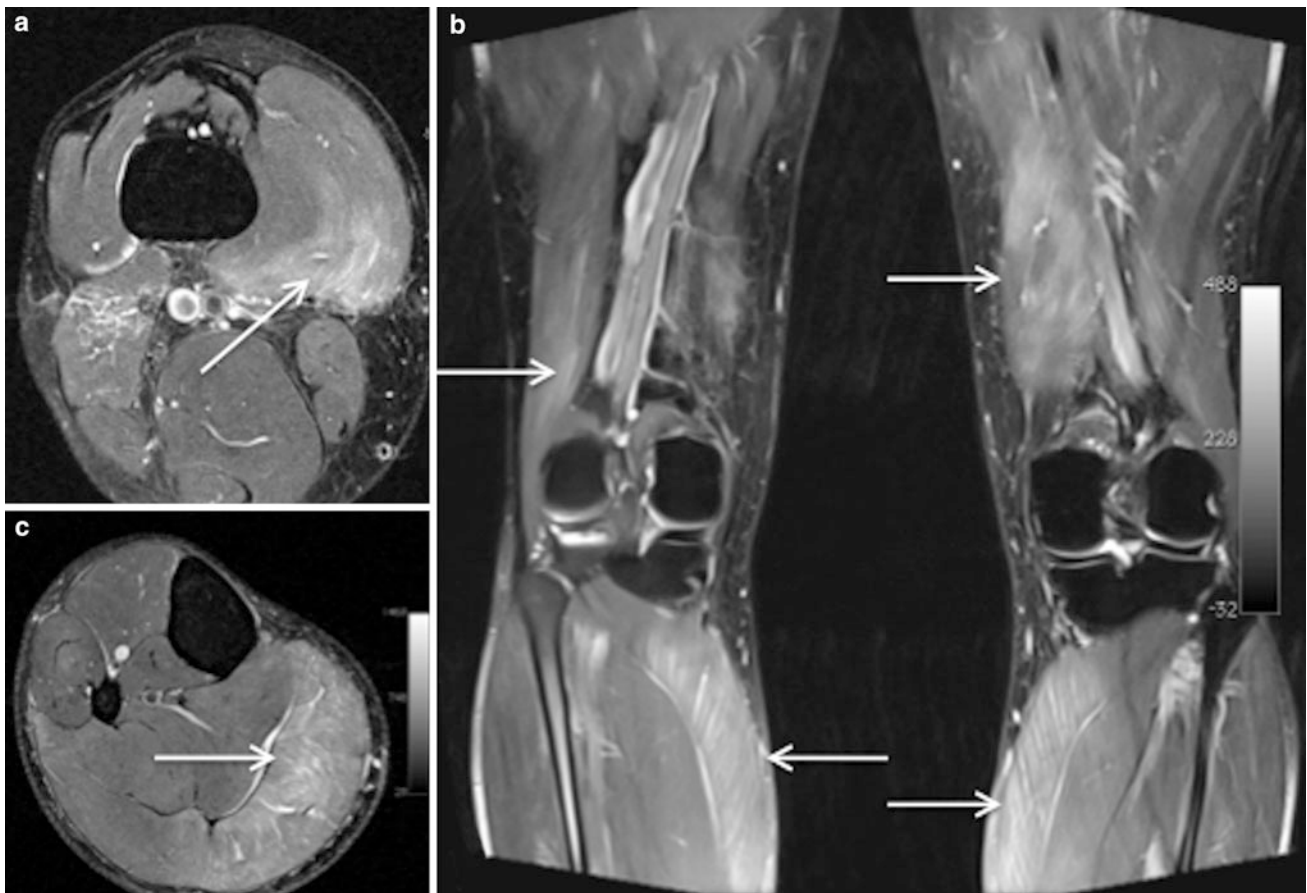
Coronal (a) and axial (b and c) proton density weighted MR images with fat saturation in an athlete with delayed onset muscle soreness 4 days post triathlon. There is extensive lower limb oedema
